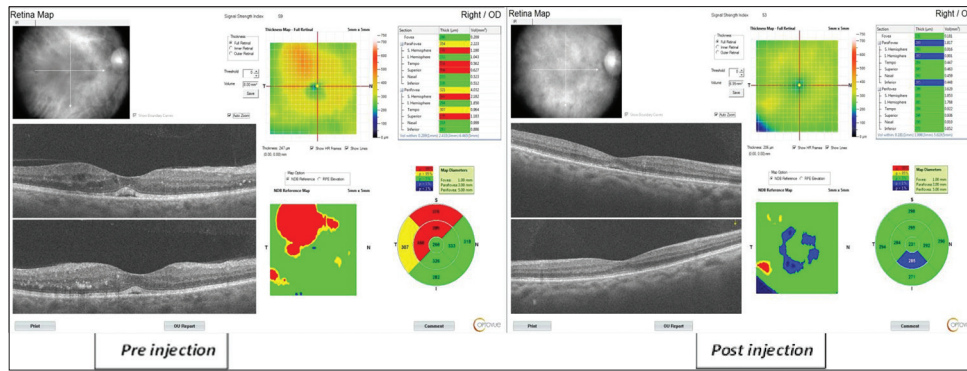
CT of preinjection and postinjection case no. 7. OCT, optical coherence tomography.
